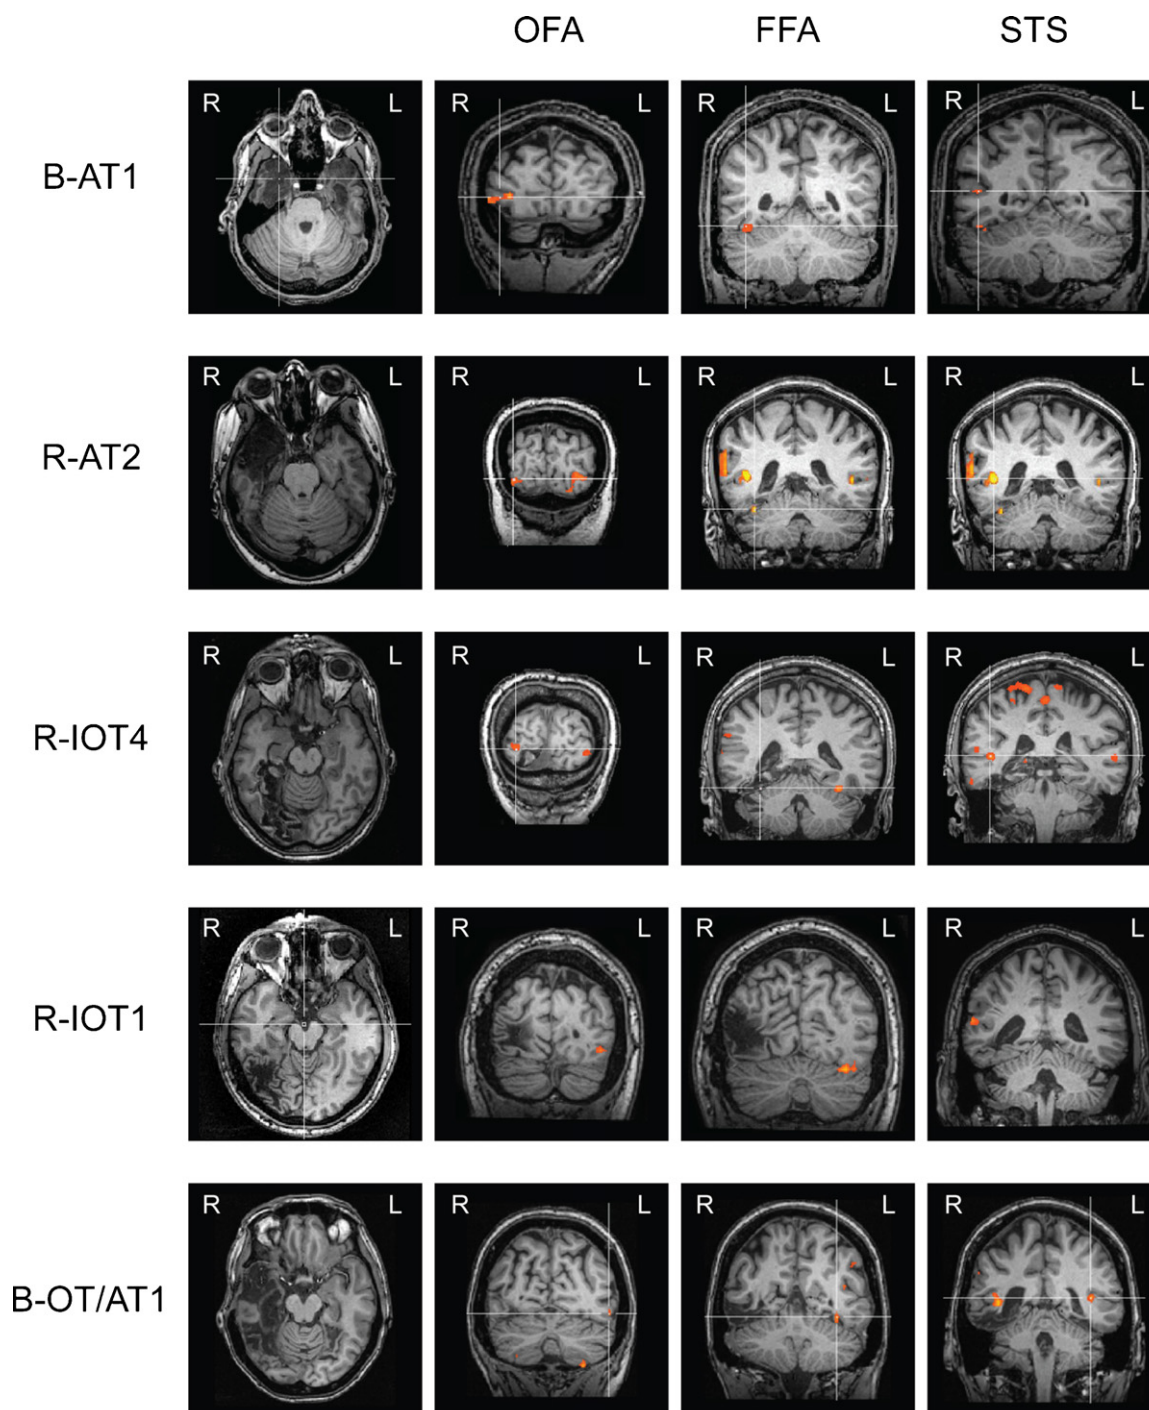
Functional neuroimaging of the five prosopagnosic patients. Left column shows a representative axial T1-weighted structural image of the main lesion in each patient. Next three columns show coronal images of the subtraction of the BOLD signal during viewing of objects from that during viewing of faces, at the level of the STS, FFA and OFA, particularly for the right hemisphere.
